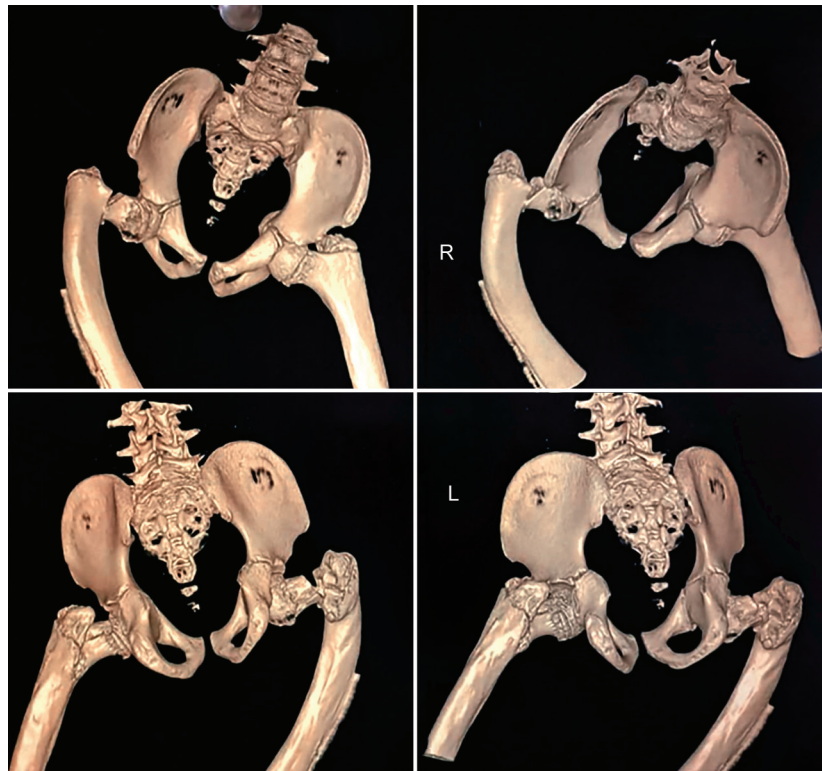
Three-dimensional CT scan showing no comminution at NOF fracture
